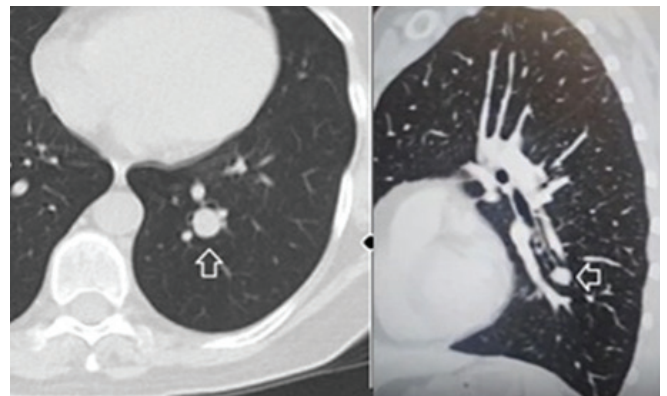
Preoperative chest CT scan demonstrating a 13-mm solid nodule located in the left lower lobe (arrow).
